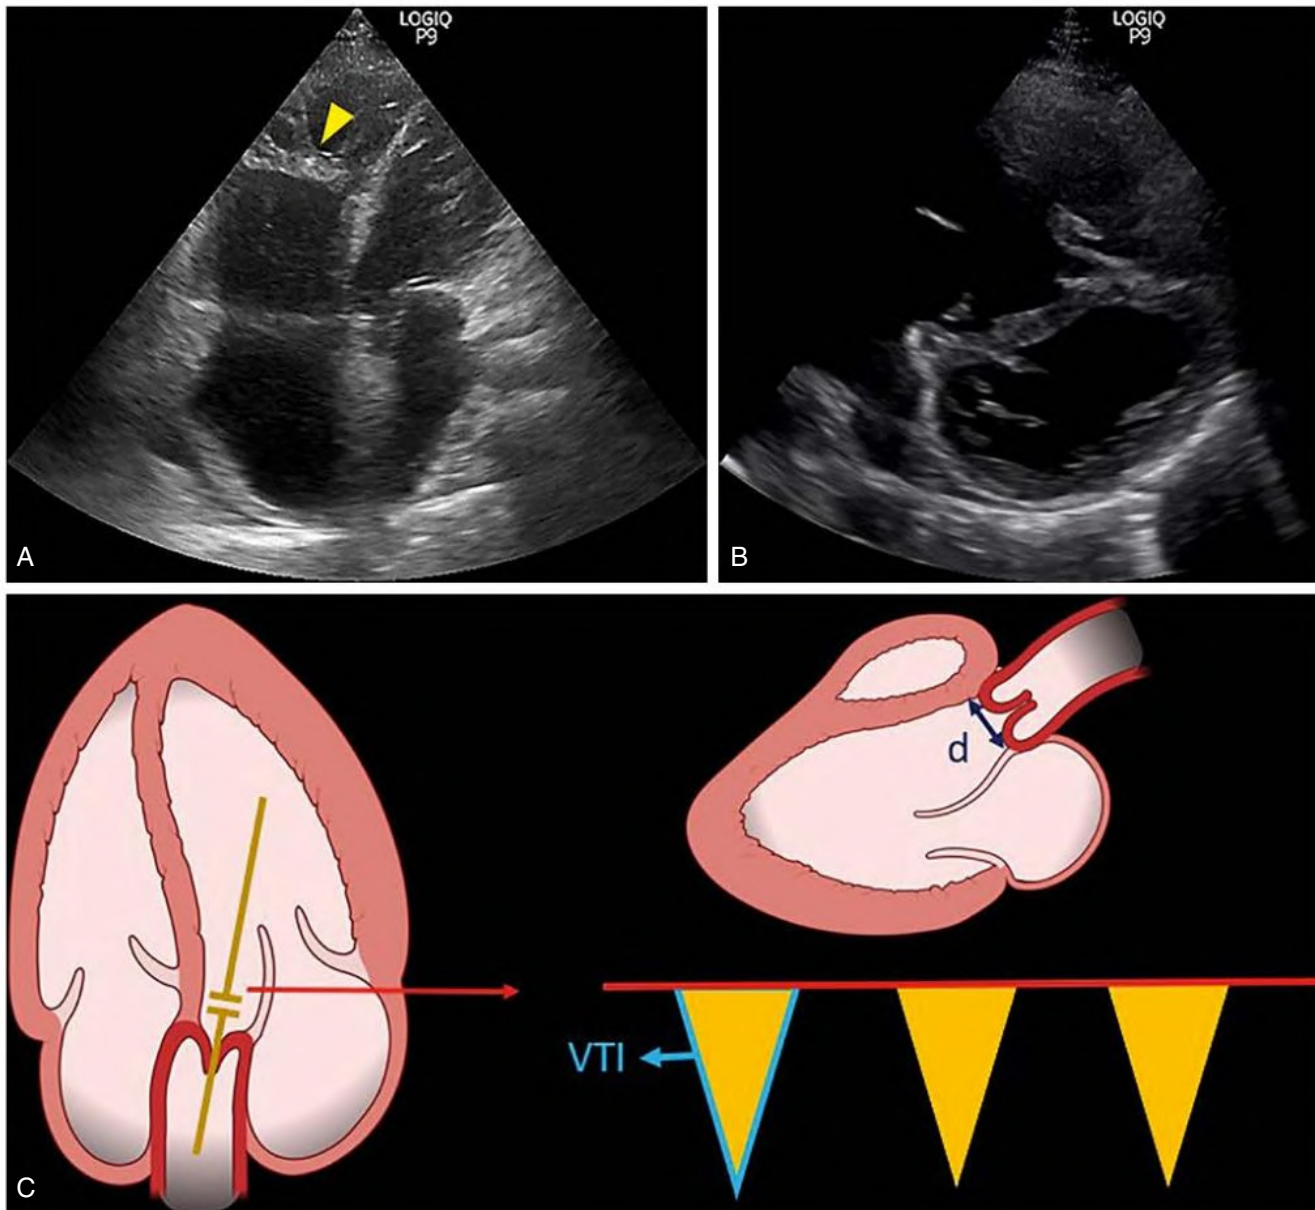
Apical four-chamber (A) and parasternal short axis (B) views obtained from a patient with severe pulmonary hypertension. Note severe enlargement of the right ventricle (larger than left ventricle in apical view) and interventricular septal flattening with D-sign on short axis. *Arrowhead* points to hypertrophied moderator band in the right ventricle. (C) Components of stroke volume assessment. Velocity time integral (VTI) is obtained by tracing the pulsed wave Doppler envelope of the left ventricular outflow tract (LVOT) in apical five-chamber view. Cross sectional area of the LVOT is obtained by measuring its diameter (d) at the base of the aortic valve in midsystole and using the formula for area of a circle, πr^2 (where r = radius, or diameter divided by 2). (Created with [Biorender.com](https://www.biorender.com).)
